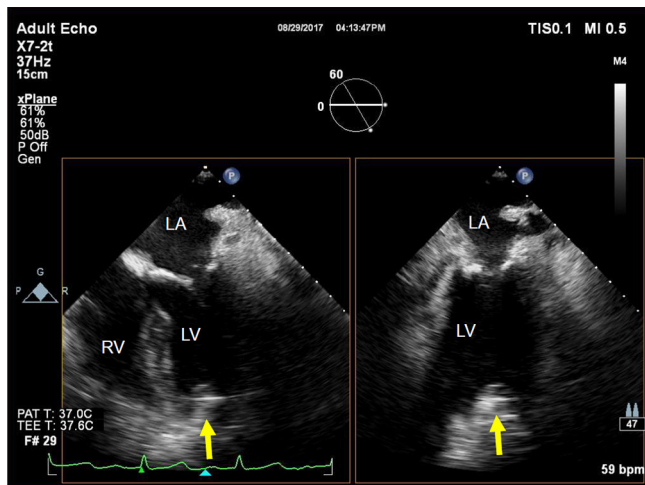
The optimal location of the apical puncture. The optimal location of the apical puncture is determined by visualizing the surgeon's fingers (yellow arrows) using transesophageal echocardiography. LV, left ventricle; LA, left atrium; RV, right ventricle.
